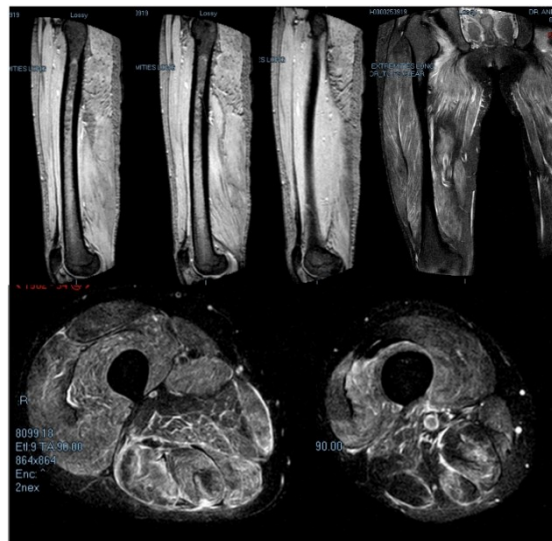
MRI findings of patient's left and right thigh muscles.
